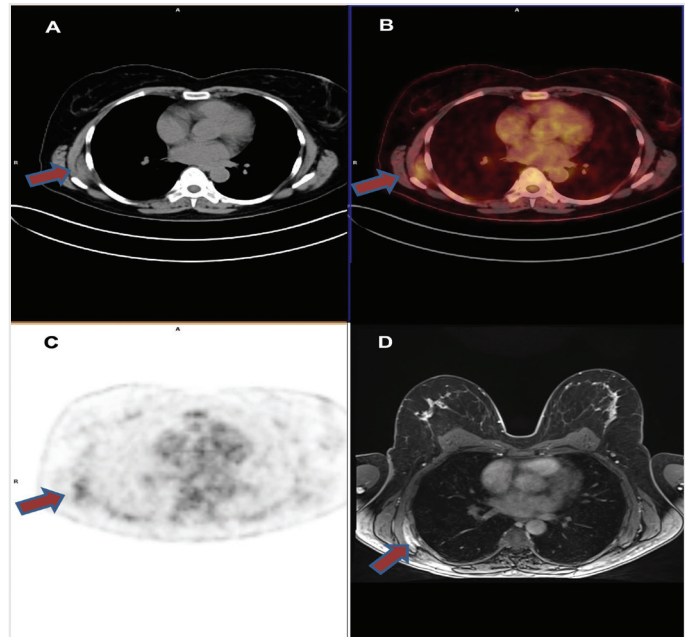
Axial slices of computed tomography (A), fusion (B), F-18 fluorodeoxyglucose (FDG) positron emission tomography (C) and T1-weighted magnetic resonance image (MRI) after contrast agent administration (D) in a 51-year-old woman with right sided breast carcinoma. Right sided, unilateral soft tissue lesion (arrows) measuring 2.4×3.2 mm and shows increased FDG uptake (SUV_{max} : 3.31) is noted. Well-differentiated unilateral soft tissue lesion with enhancement is noted on MRI
